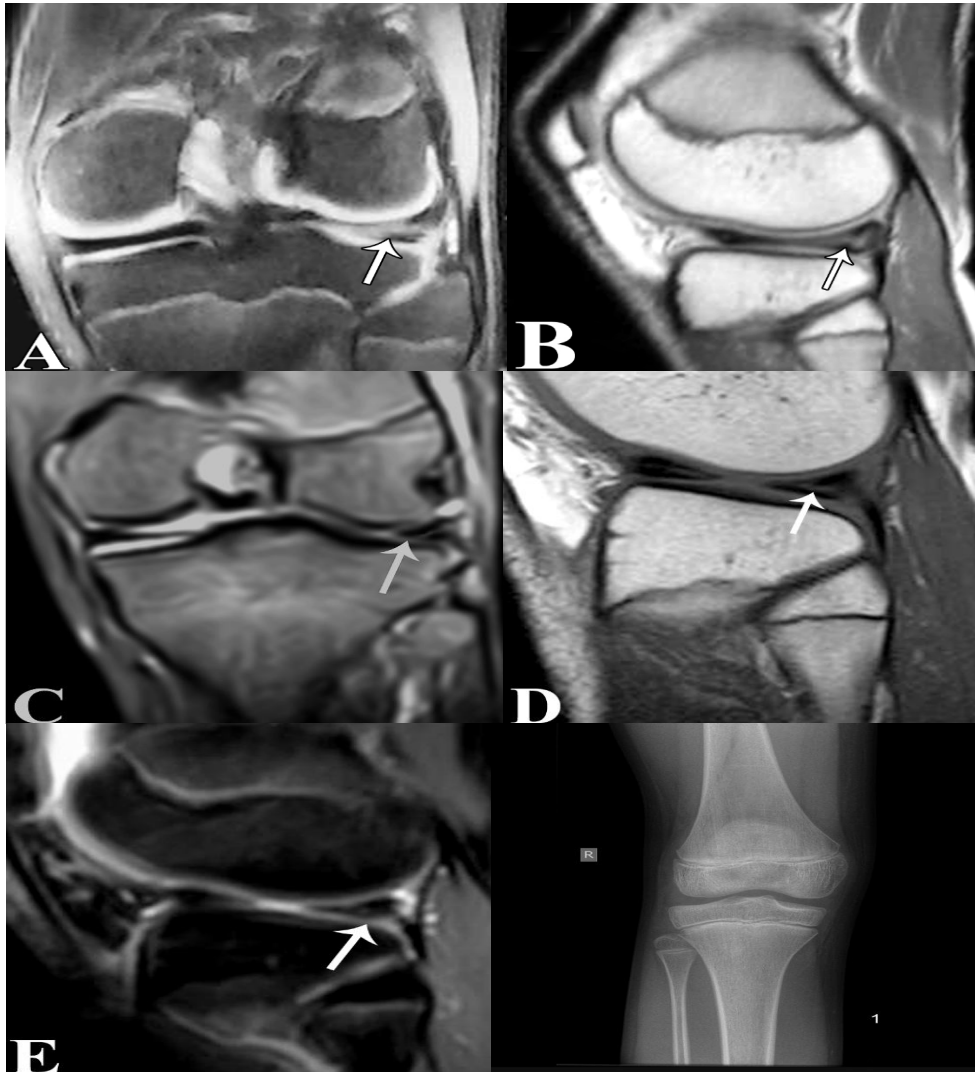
Pre-operative MRI, Post-operative MRI, and Plain x ray of knee
